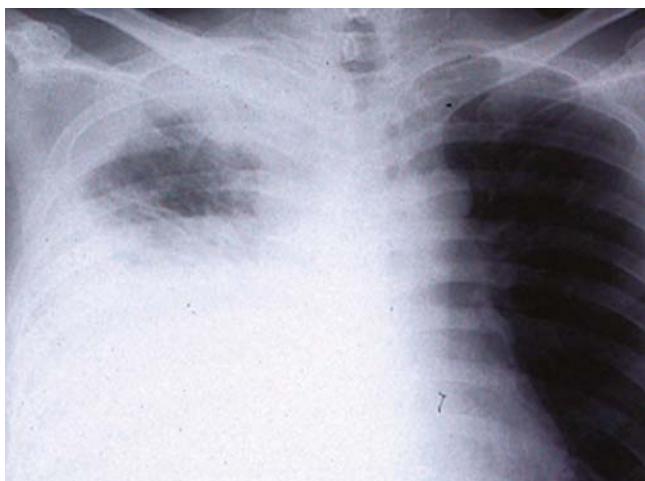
Radiograph of chest showing partial re-expansion of the right lung following drainage of the pleural effusion. Reproduced with permission from *Acta Medica Okayama*, see chapter references for complete citation.
